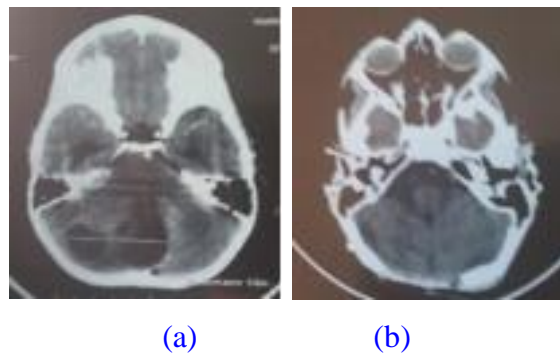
Pilocytic astrocytoma FCP MRI Pre (a) and post(b) operative
